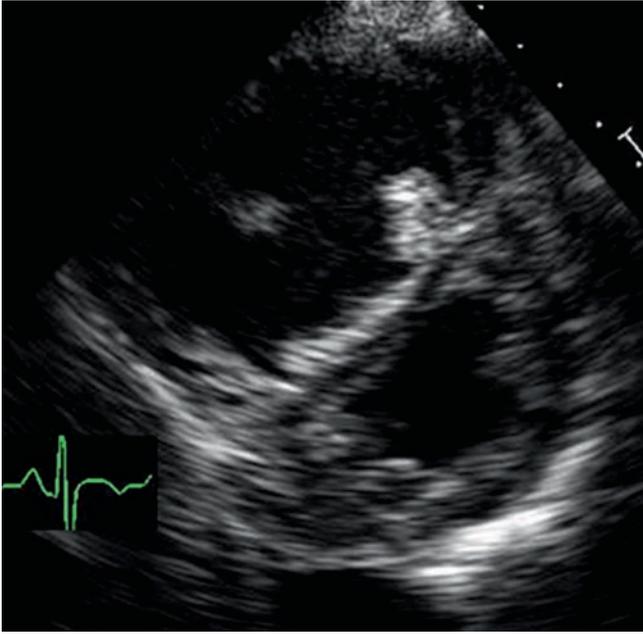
Septal flattening in pulmonary hypertension. Parasternal short-axis view. The inter-ventricular septum is flat in systole due to the elevated pulmonary pressures. Due to the flattening, the LV has the configuration of a capital D
